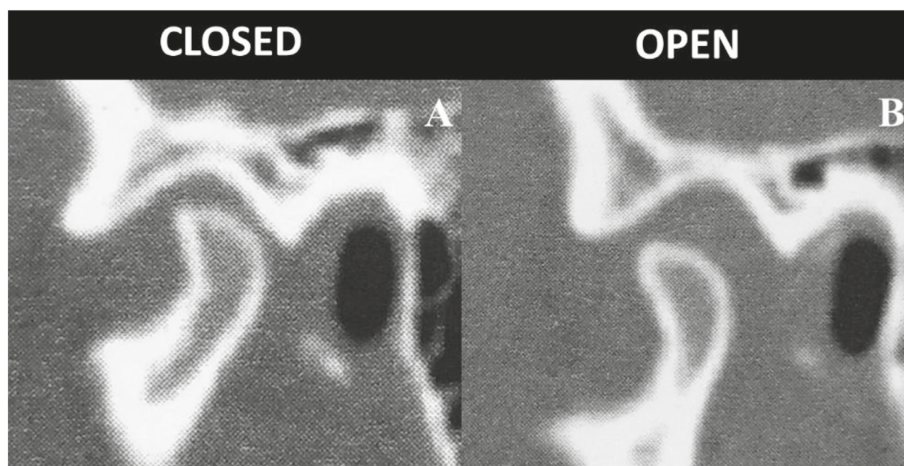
Follow-up multidetector computed tomography of the right temporomandibular joint six months post-intervention. (A) Closed-mouth view demonstrating complete recorticalization of the mandibular condyle (compare with Figure 1A). (B) Open-mouth view showing maintained cortical integrity during function. (A) Closed-mouth view demonstrating complete recorticalization of the mandibular condyle (compared with Figure 1A). (B) Open-mouth view showing maintained cortical integrity during function.
